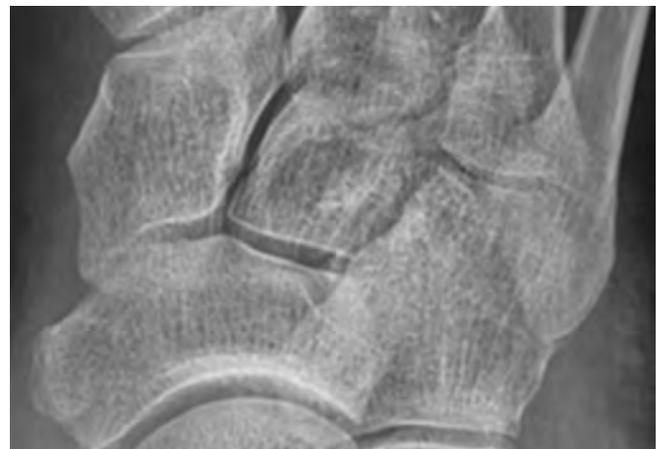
Landmarks of the fourth and fifth metatarsocuboid joints. The lateral aspect of the fifth metatarsal cuboid joint is very difficult to identify in this anterior-posterior weight bearing radiograph due to overlap of the cuboid and styloid process of the fifth metatarsal. However, the lateral aspect of the fourth metatarsal cuboid joint is easily identified in this subject.
